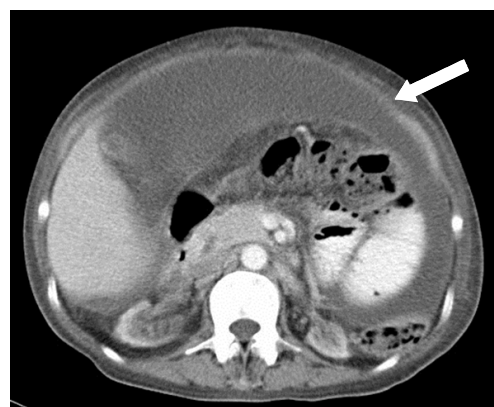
Axial CT abdomen demonstrating thickened peritoneum (arrow) with ascites and tethering of the bowel.
